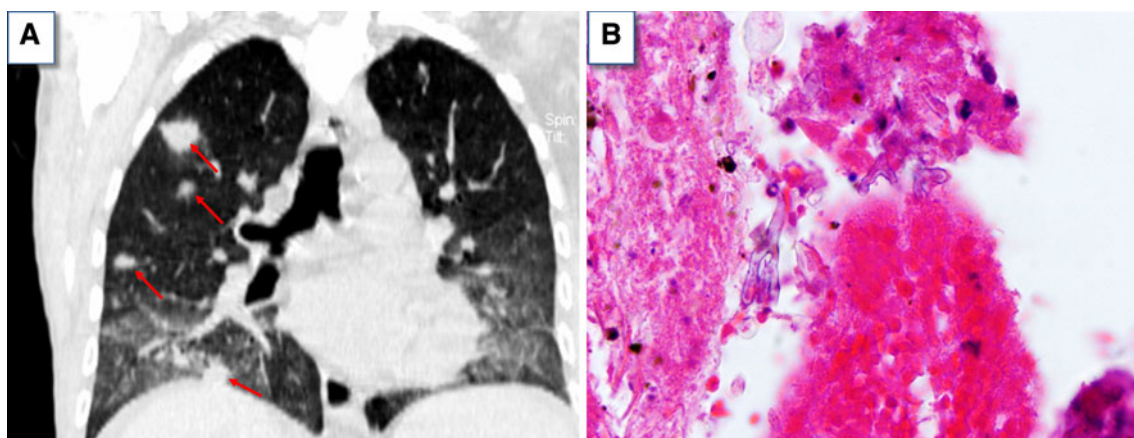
a Coronal section of computed tomography (CT) of the chest showing multiple fungal balls (*arrows*) throughout the right lung and bibasilar ground-glass opacities due to pneumonia. b Lung biopsy
